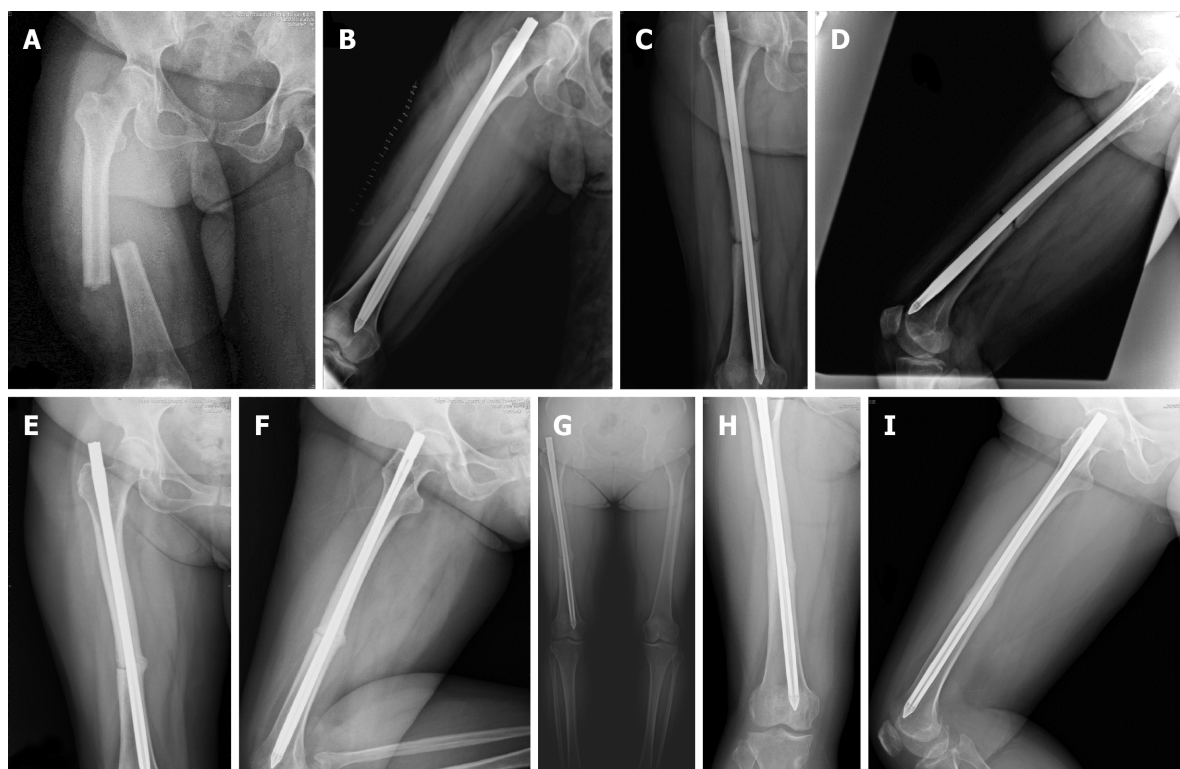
Radiographs of the femur. A: Anteroposterior view. Right femoral shaft fracture, middle third, simple transverse. Date: April/12/2016; B: Lateral view. Status after the closed reduction internal fixation with the Fixion nail. Date: April/13/2016; C: Anteroposterior view, 6 mo postoperatively, one month before the teriparatide treatment. No callus was observed. Date: Oct/20/2016; D: Lateral view. Date: Oct/20/2016; E: Anteroposterior view, 3 mo after teriparatide use. A callus was observed. Date: Feb/21/2017; F: Lateral view. Date: Feb/21/2017; G: Anteroposterior view, 5 mo after teriparatide use. Continuous improvement in fracture gap reduction and bone bridging was observed. Date: April/21/2017; H: Anteroposterior view, 6 mo after the discontinuation of teriparatide. A complete union was observed. Date: Nov/14/2017; I: Lateral view. Date: Nov/14/2017.
